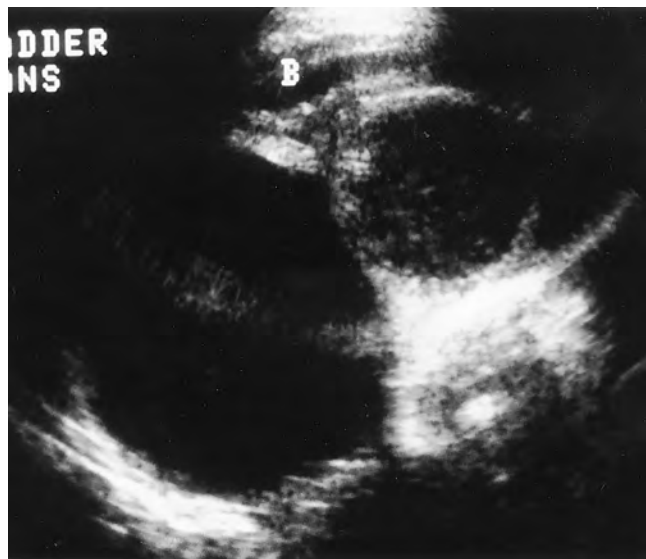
Pelvic ultrasonography in a patient with a cloaca. Duplicate fluid-filled vaginas are seen posterior to the decompressed bladder (B).
